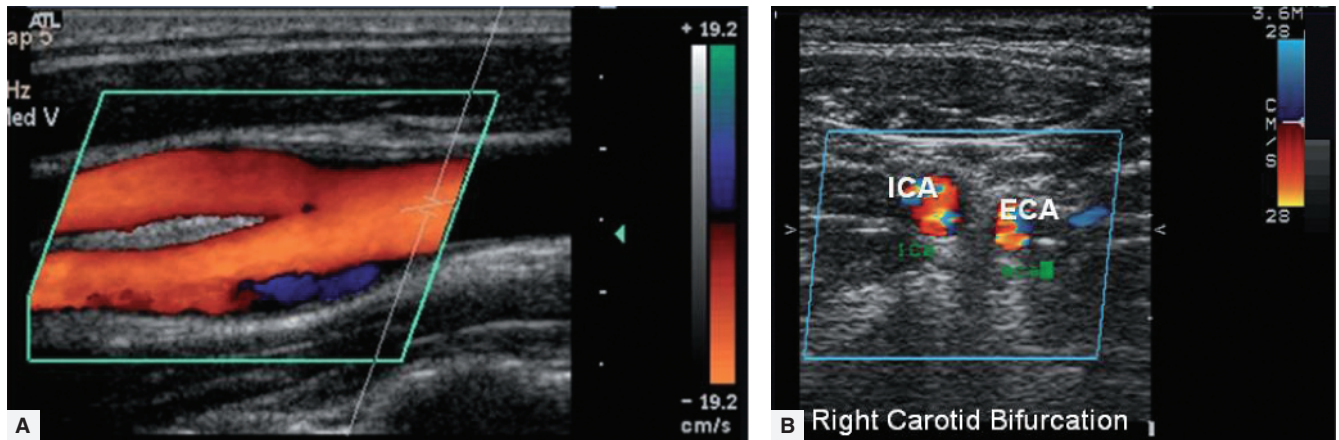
(A) Color-flow image of a normal carotid bifurcation. The color bar on the right of the image indicates flow towards the probe is blue and away from the probe is red. Note the black line separating the blue and red on the color bar indicates no Doppler shift. Therefore when the color on the image goes from red to black to blue this
